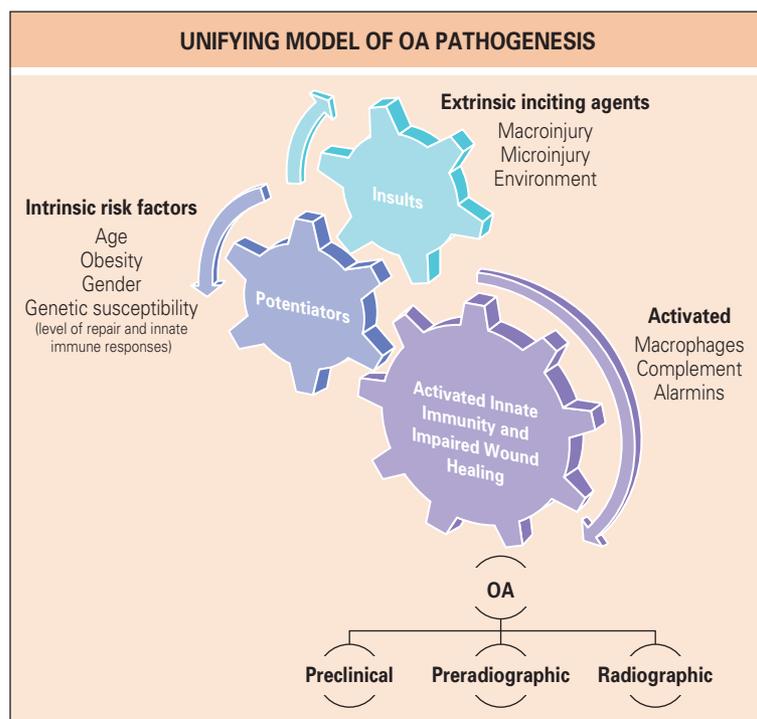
This model depicts osteoarthritis (OA) as a condition incited by mechanical insults of microinjury, macroinjury, and environmental factors. The interaction of extrinsic inciting insults with potentiating intrinsic factors determines the relative susceptibility to progression of disease mediated by a biologic innate immune inflammatory response analogous to a chronic wound. The resulting pathology is manifest first as a preclinical (not clinically recognizable) entity, with progression in some individuals to preradiographic stages (detected by sensitive imaging modalities) and eventually to radiographic stages. The interacting cogwheels, able to turn intermittently, depict the penchant for OA activity to wax and wane. The exact timing of the onset of the illness of OA that includes symptoms in this continuum of OA pathogenesis is unclear at present.
